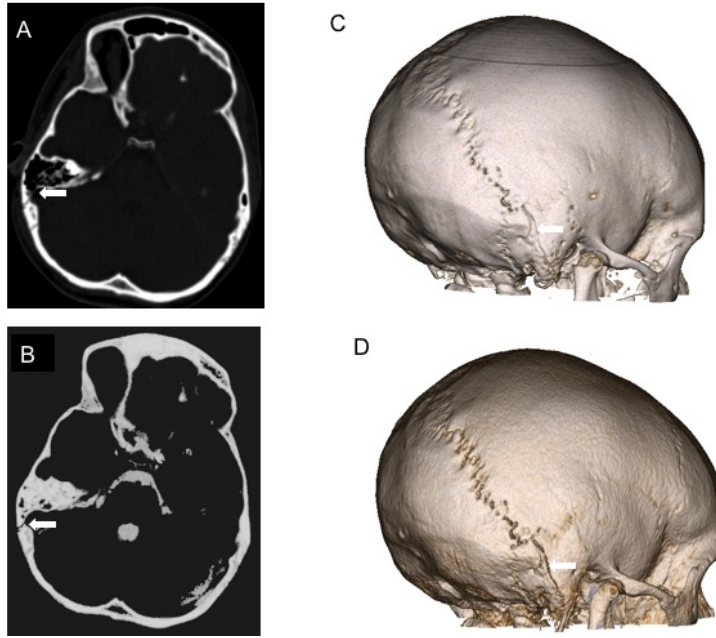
14 years old, occipital bone fracture. Arrows indicate a fracture. CT axial volumetric sample (A). CT 3D-reconstruction (C). pCT axial volumetric sample (B) and pCT 3D-reconstruction (D).
